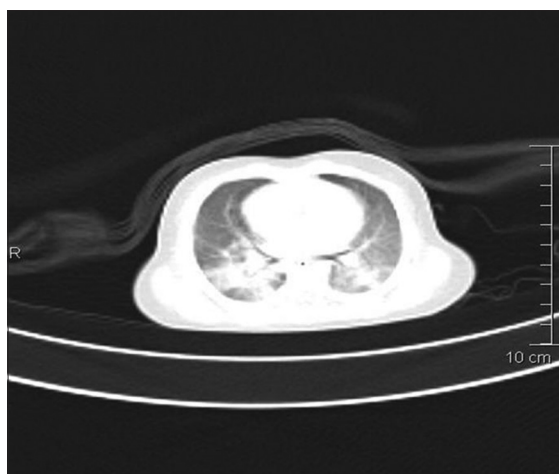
Computed tomography chest showing diffuse airspace opacities predominantly in the lower lobes bilaterally
